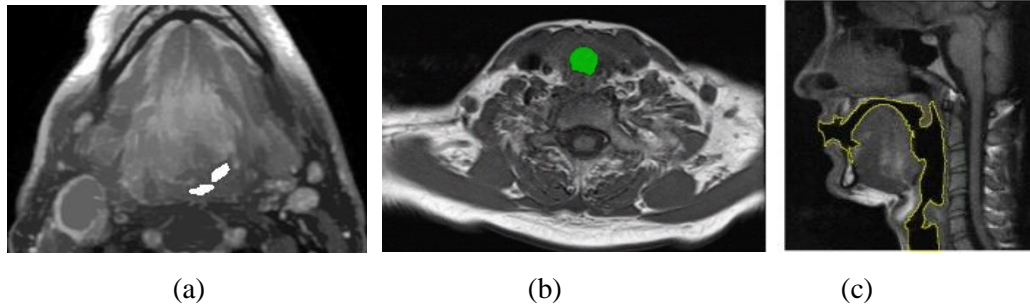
MR image showing segmented (a) throat region (white region) [11] © 2014 IEEE (b) trachea region (green region) [95] © 2011 IEEE (c) vocal tract outline (yellow outline) [93] © 2009 IEEE.
